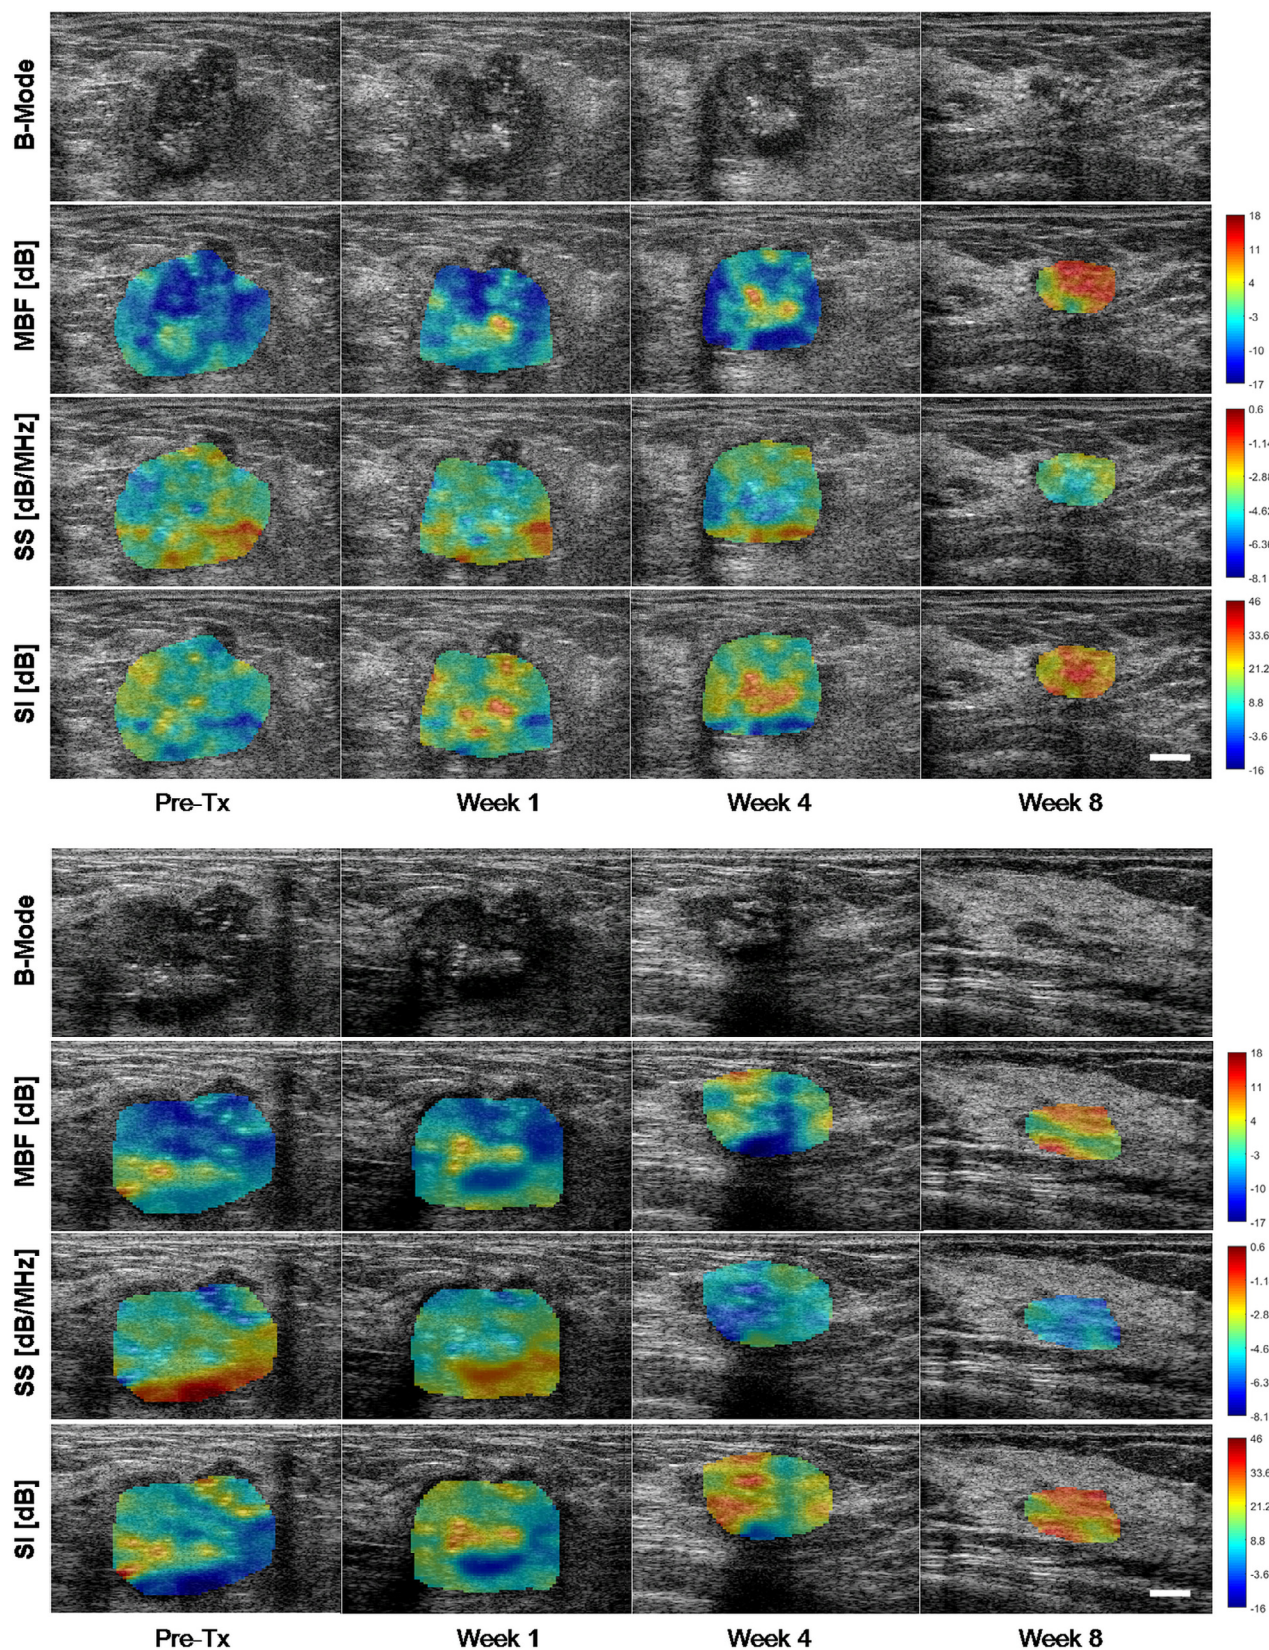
B-mode MBF, SS and SI parametric images from a responder before treatment (Pre-Tx) as well as at weeks 1, 4 and 8 during treatment acquired using the ULX (*top*) and GE (*bottom*) systems. The *white scale bars* in ultrasound images represent 5 mm.
